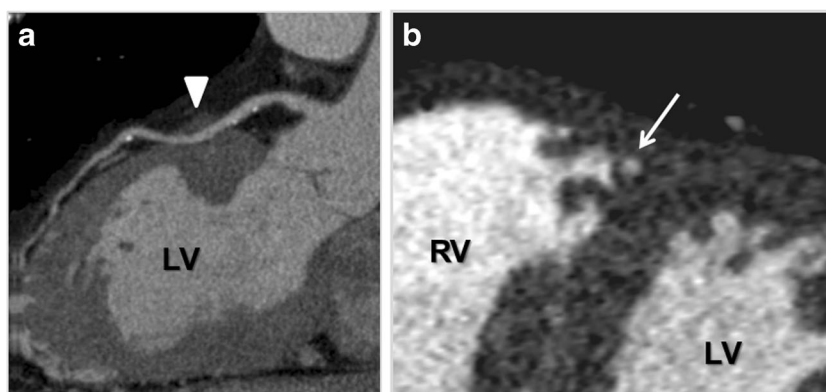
A 67-year-old female presented with atypical, non-exertional chest pain and underwent coronary CTA. a An oblique sagittal image demonstrates a left anterior descending artery bridge as it courses deeply
